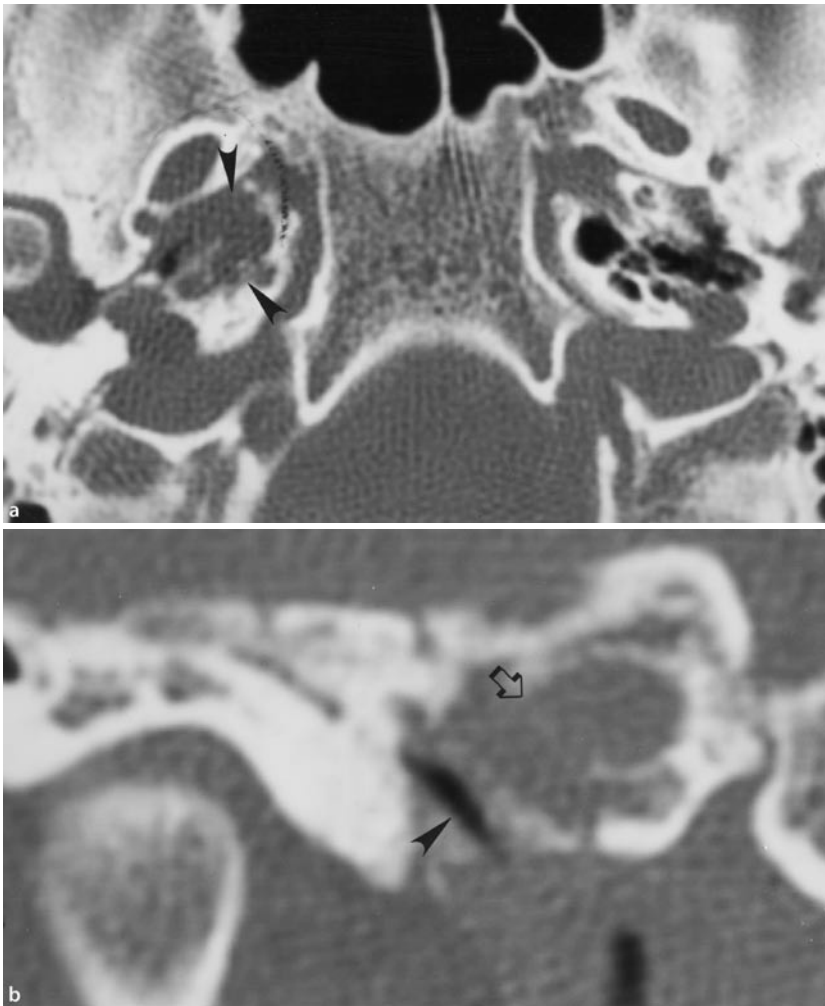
a Patient with chronic otitis media and retro-orbital pain. Axial CT scan demonstrates opacification of petrous apex air cells with decalcification of bony trabeculae (*arrow*). The contralateral petrous apex is normal. b Coronal CT of same patient shows erosion of the carotid canal (*arrow*) and air in the Eustachian tube (*arrowhead*)
